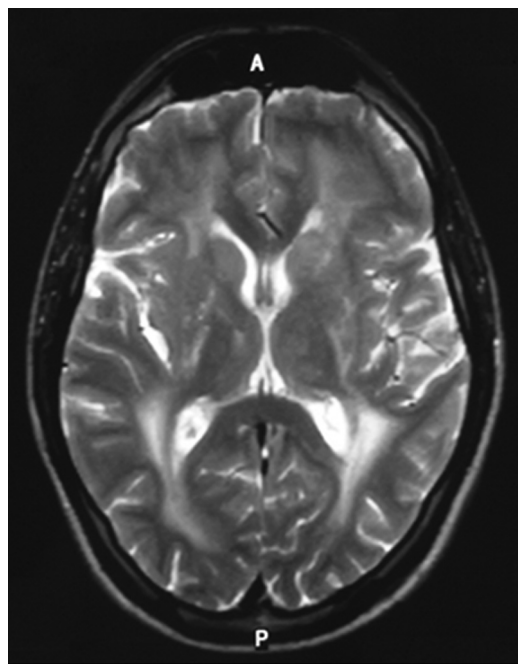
MRI of patient 3. Axial T2-weighted MRI scan showing diffuse white matter high signal sparing the U fibers. Multiple high signal abnormalities are visible in the basal ganglia and thalami. MRI, magnetic resonance imaging.
